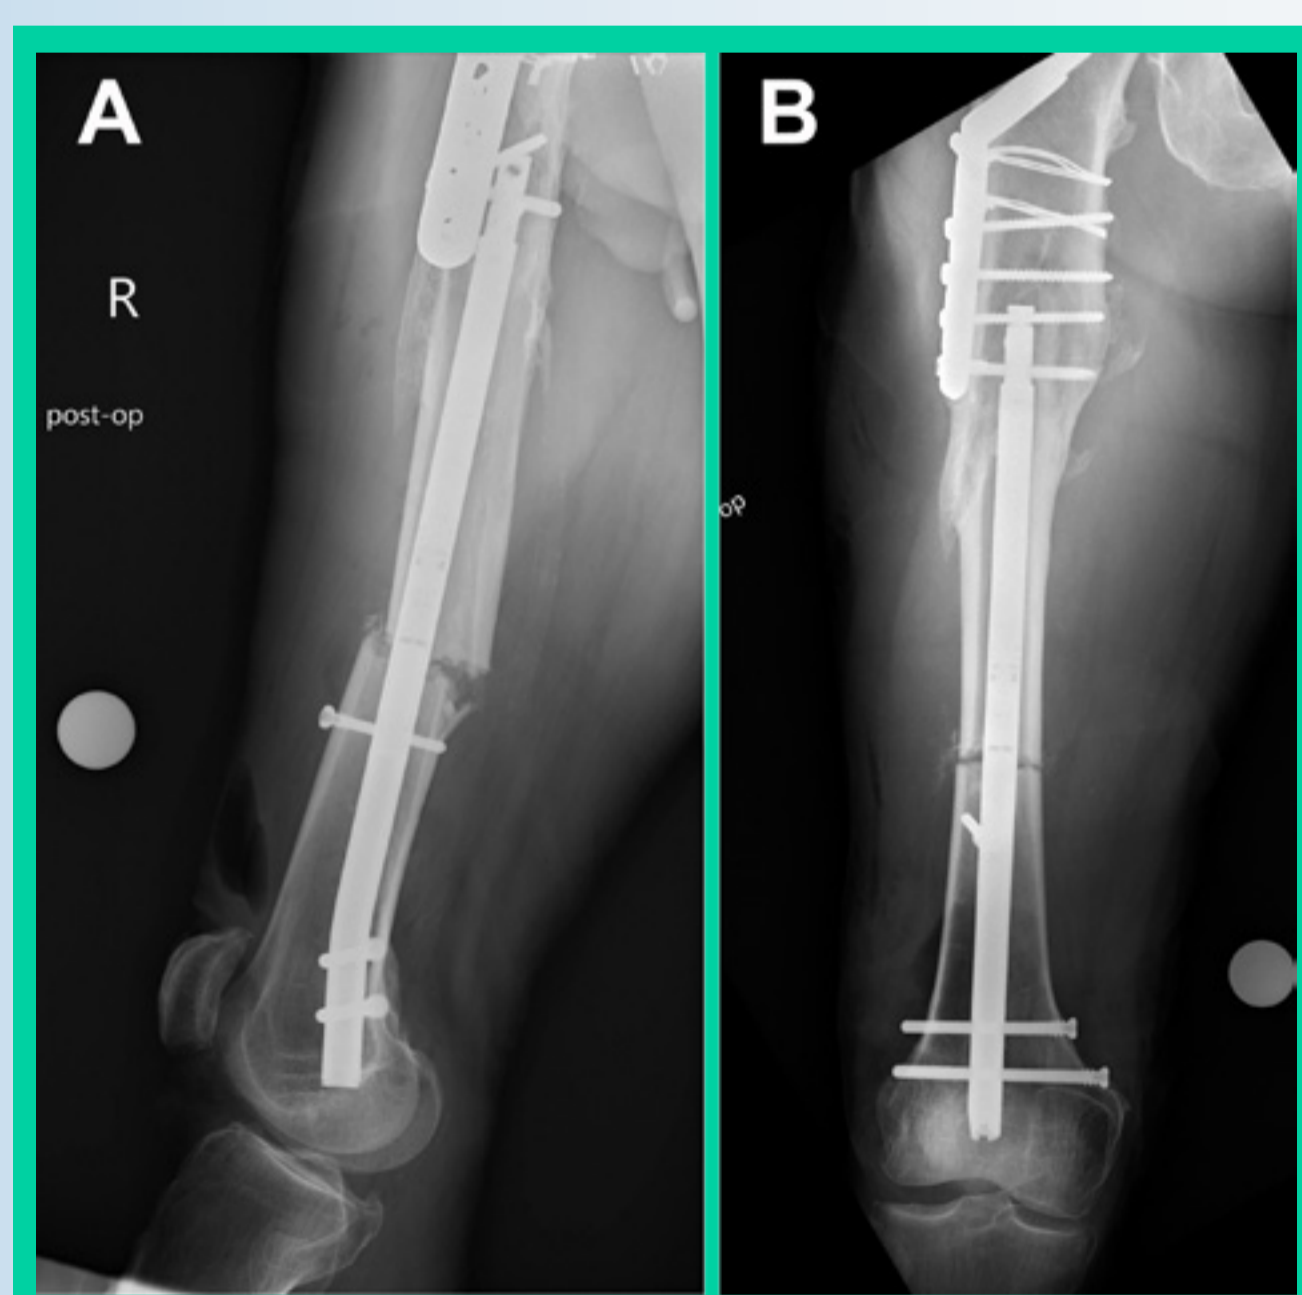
Immediate postoperative lateral (A) and AP (B) view radiographs of the affected femur after insertion of the motorized magnetic lengthening nail.
